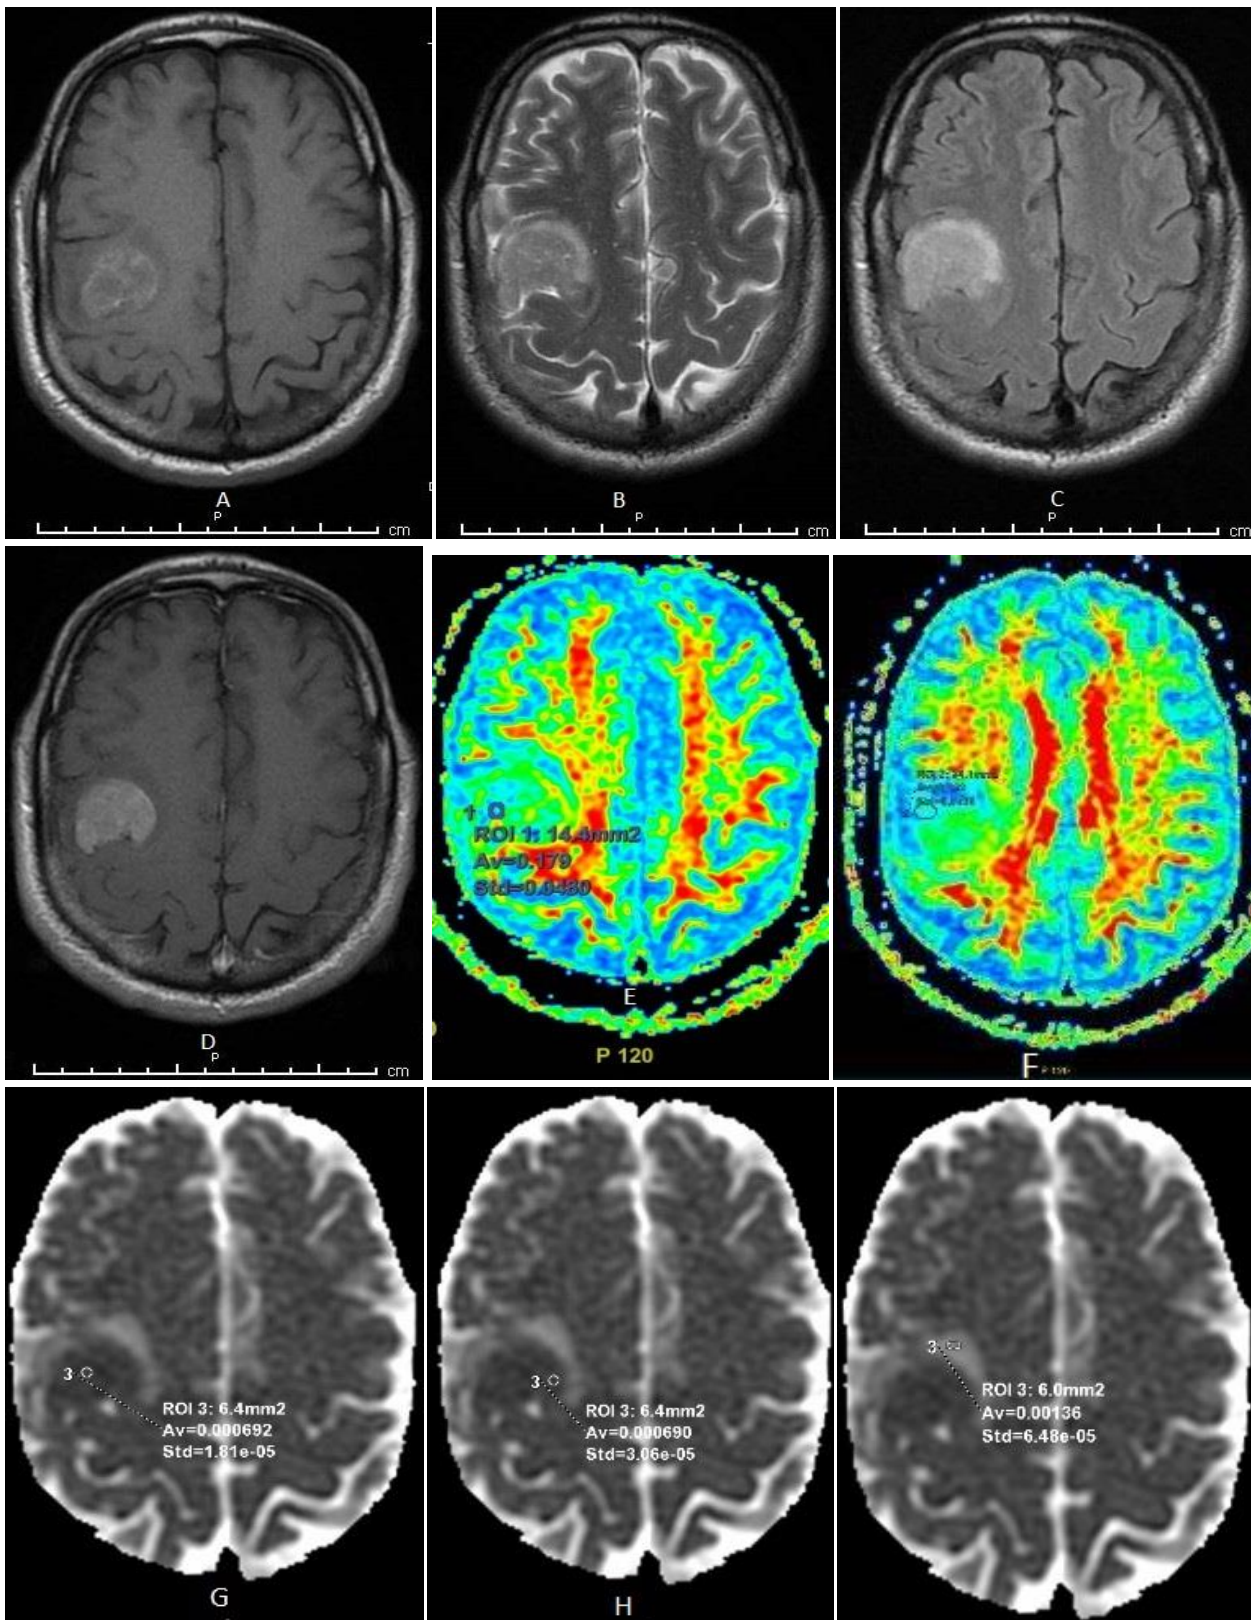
Male patient 51 years old with pathologically proved metastatic melanoma (A), (B) and (C) images Axial T1, T2 and FLAIR images respectively, showing right parietal intra axial lesion with surrounding vasogenic edema and heterogeneous post contrast enhancement (D). (E) and (F) FA map with two regions of interest measured within the enhancing part of the tumor and within the immediate peri-tumoral edema demonstrate slightly elevated FA value in the immediate peri-tumoral edema, (G) and (H) ADC map with two regions of interest measured within the enhancing part of the tumor and (I) within the immediate peri-tumoral edema
